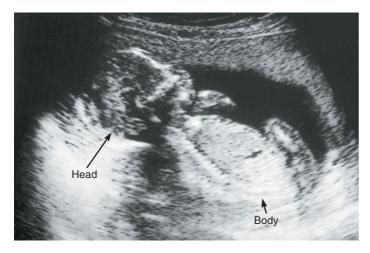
Ultrasound image of a fetus in the uterus.
